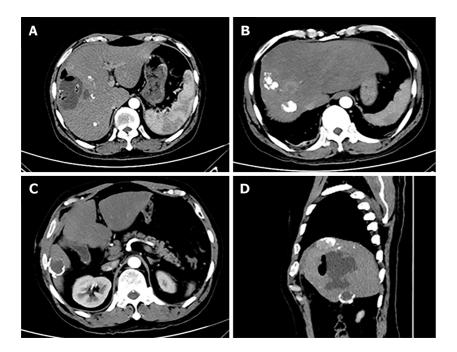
Abdominal computed tomography scanning in the second hospitalization. A: The plane of liver abscess; B: The plane of hepatocellular carcinoma; C: The plane of hepatic cystic echinococcosis; D: The reconstruction of computed tomography image.
